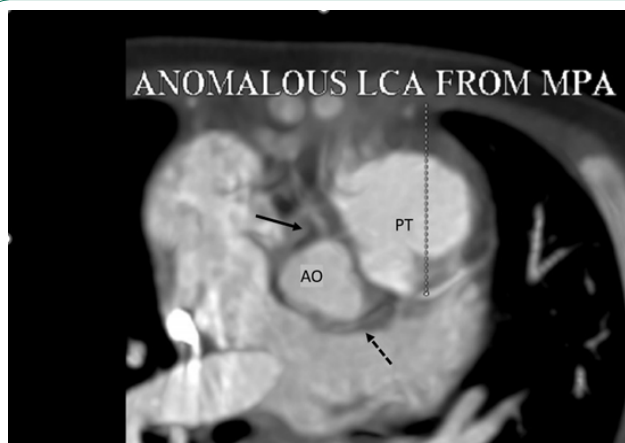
Computed tomographic angiography shows anomalous origin of the left coronary artery from the pulmonary trunk (ALCAPA). Note the origin of right coronary artery (RCA) from right coronary cusp (line arrow) and absent left coronary artery from left coronary cusp (dotted arrow). Ao=aorta; PT=pulmonary trunk.
